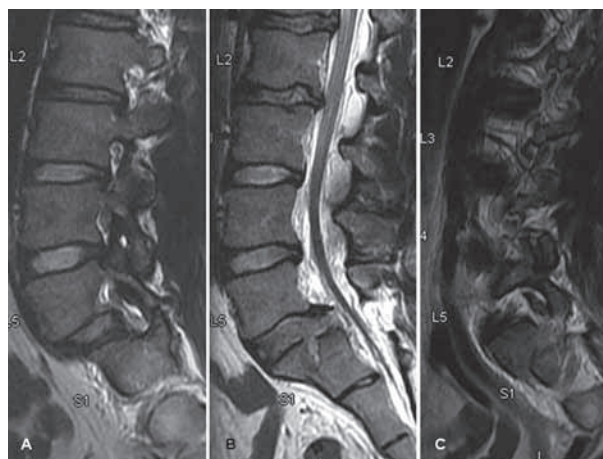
Sagittal T2-weighted MRI showing (A) dislocation of the left L5S1 facet joint, (B) disruption of the ligamentum flavum, posterior longitudinal ligament and posterior disc, and an intact-looking anterior longitudinal ligament at the L5S1 junction, and (C) fractured right superior articular process of S1 displaced anteriorly compromising the neural foramen.
